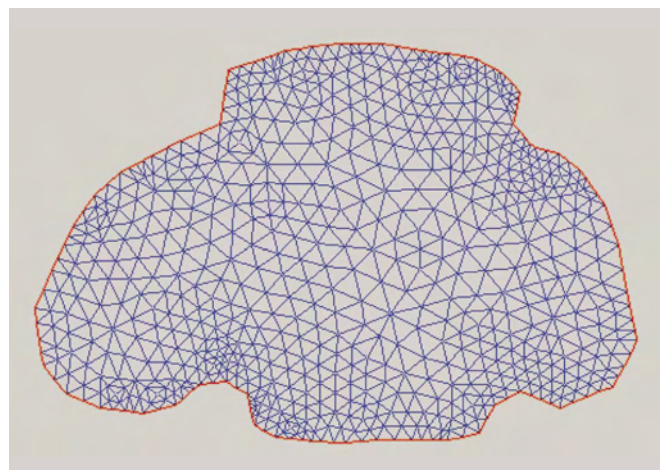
FEM mesh constructed from the anatomical MR image.
